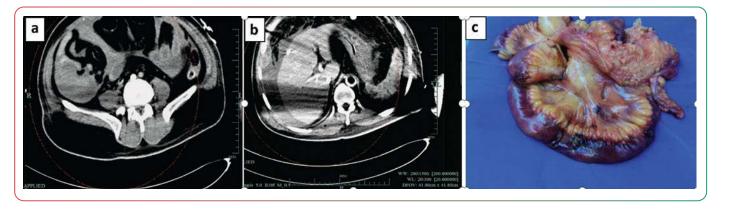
a and b) Preoperative abdominal computed tomography. a) CT showing ileocaecal effusion. b) CT showing perihepatic effusion. c) Postoperative intestinal perforation and necrosis.
